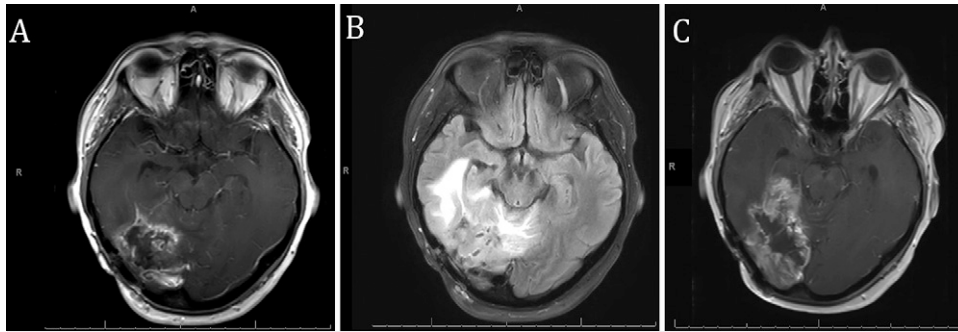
A: Axial postcontrast T1-weighted MRI showing no evidence of recurrence within resection bed at 1 month. B: Axial T2-weighted fluid-attenuated inversion recovery MRI showing increased edema around ablation site at 1 month. C: Axial postcontrast T1-weighted MRI showing tumor recurrence at 9 months postoperatively.
